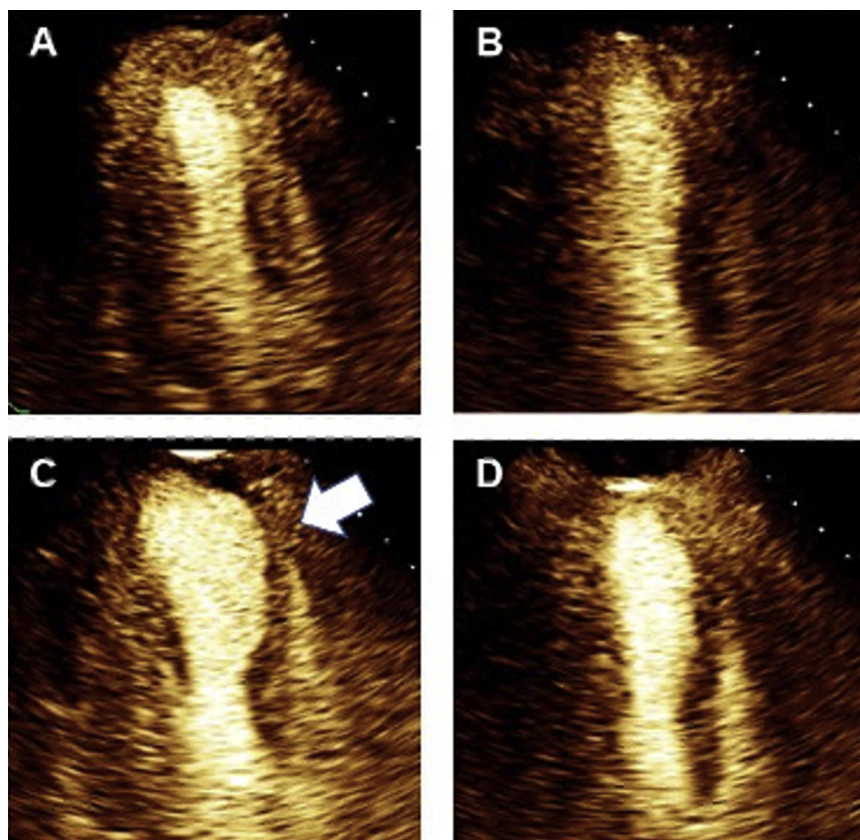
Contrast echocardiography. Contrast echocardiography in the apical three-chamber (long-axis) view during graded supine bicycle exercise stress echocardiography in a patient who required ultrasound-enhancing agents for left ventricular. End-systolic images are shown (A) at rest, (B) early in exercise, (C) at peak exercise, and (D) during recovery. At peak stress, the lack of endocardial excursion of the anteroseptal segments (arrow) can be appreciated.
